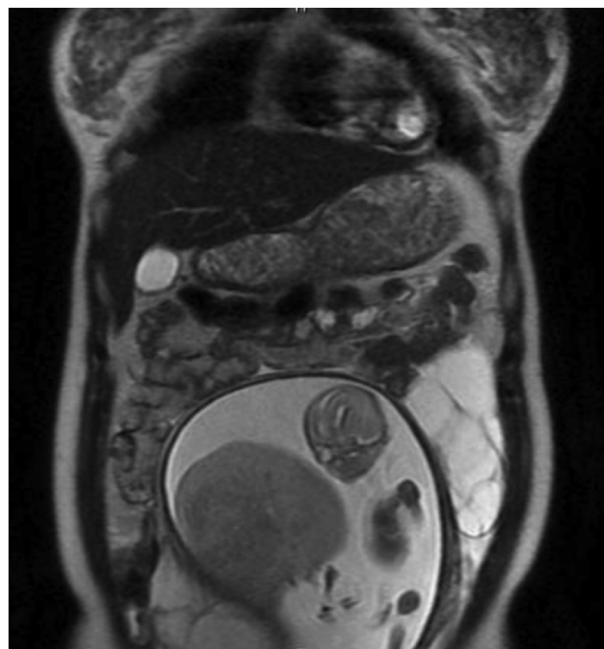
MRI T2 Coronal view. A 12 cm hyperintense cystic multiseptum mass at left ovary. A fetus in uterus noted.
